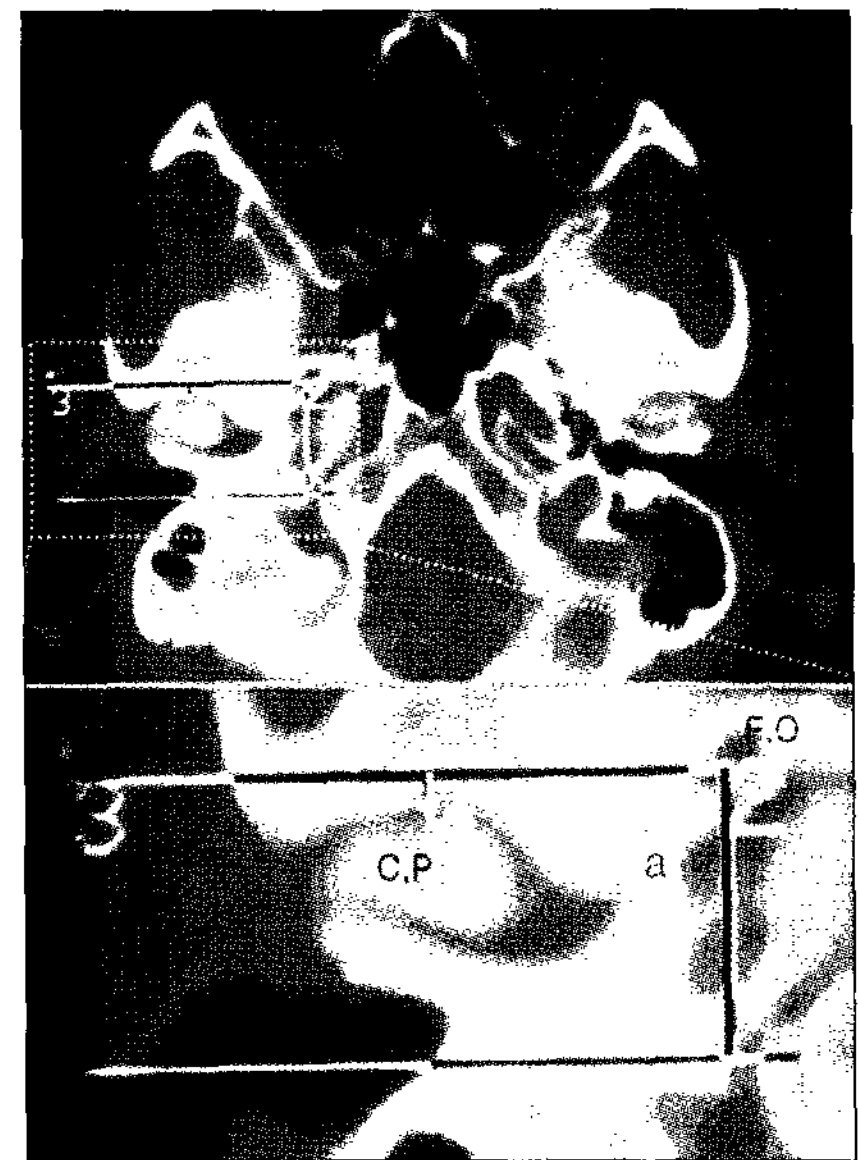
Localization of zygomatic point (3: red point indicated by red arrow) by facial axial computed tomography using the orbitomeatal plane, a (1-2) : distance between external acoustic meatus and zygomatic point (3), b : distance between anterior margin of condylar process (4) and zygomatic point (3).
